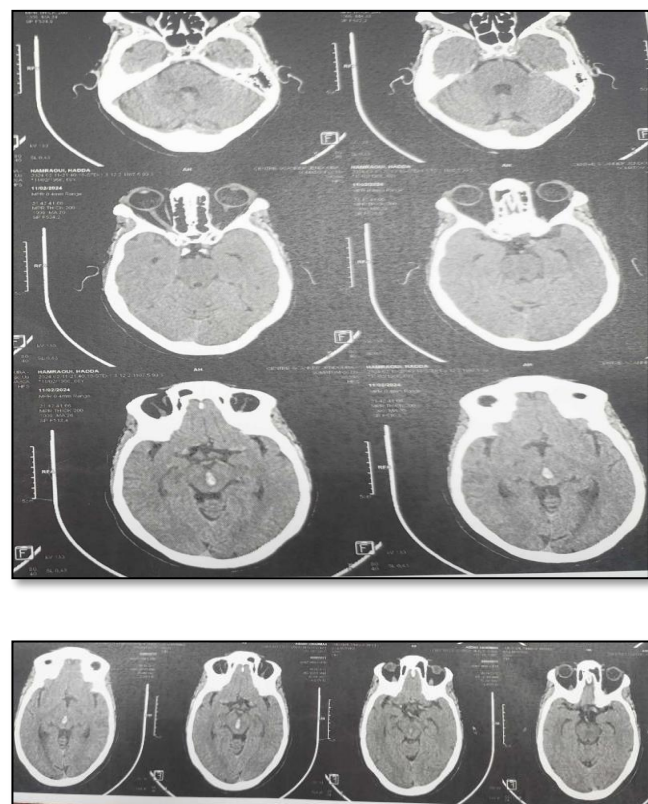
Computed tomography scan showing hemorrhage in the midbrain tegmentum.
